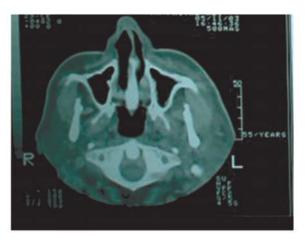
CT scan cervical region did not show any extension of the mass into the neck.
